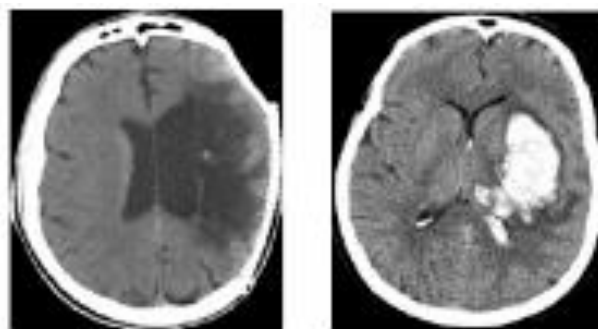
CT scan images showing a hemorrhagic stroke (left), indicated by a dark area, and ischemic stroke (right), indicated by a bright white area. Adapted from [18].
